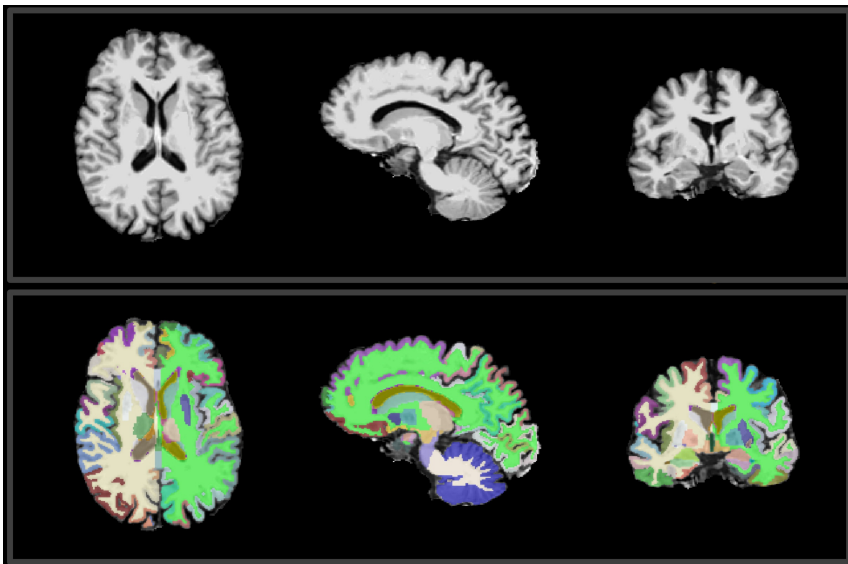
T1-weighted brain MRI and FreeSurfer segmentation. Example of a T1-weighted brain MRI (top) and the corresponding FreeSurfer parcellation/segmentation overlay according to the Desikan-Killiany atlas (bottom).
